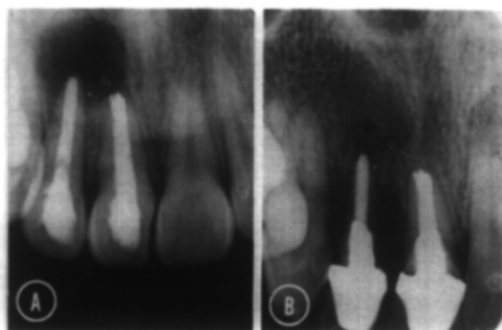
Case 248 (same as in Figs. 2, 4, B, and 5, A). A, Immediate postoperative radiograph following obturation with gutta-percha of teeth 7 and 8 and curettage of the apical areas with an apical amalgam placed in tooth No. 8. B, Follow-up radiograph taken 4 years postoperative showing complete healing of tooth No. 8 and considerable reduction in the size of the lesion around tooth No. 7.
